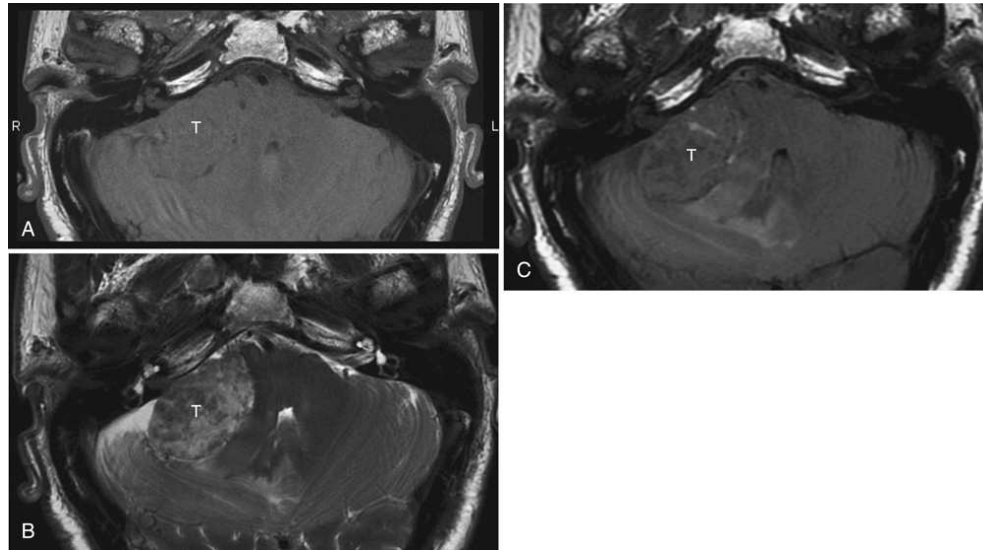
Axial magnetic resonance imaging (MRI) showing the use of different pulse sequences and their effect on the visualization of the cerebellopontine angle tumor. (A) T₁-weighted image shows that limited contrast exists between the tumor (*T*) and normal brain. (B) The lesion becomes dramatically more obvious using the pulse sequence of the T₂-weighted image. (C) The lesion is still visible on a FLAIR pulse sequence, but not as well as in the T₂-weighted image. Choice of pulse sequence is critical. These images also show how the lack of bone artifact makes MRI superior to CT for imaging of posterior fossa lesions.
